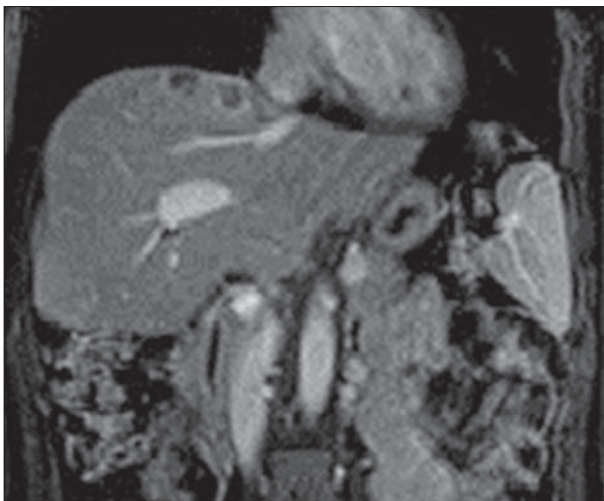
Liver MR imaging performed 13 months after the surgery (on the same 3T scanner): coronal post-contrast T1W image demonstrates multifocal tumour recurrence, two hypointense nodes with rim enhancement
